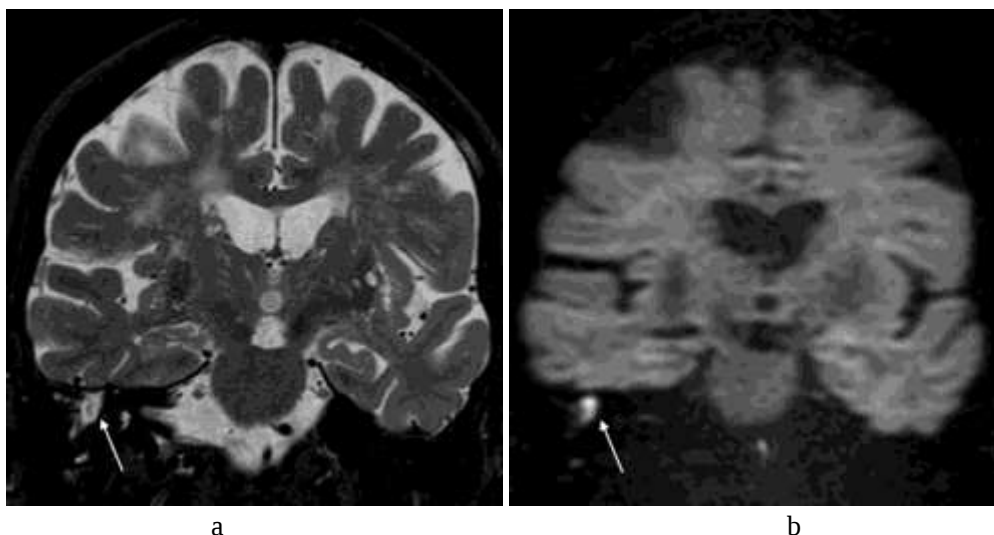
Chronic otomastoiditis with cholesteatoma (same patient shown in figure 12); coronal T2-weighted fast spin echo sequence with fast saturation (a) showing unspecific high signal intensity inflammatory tissue in the middle ear cavity (white arrow). A coronal non-echo planar DWI sequence (b) well demonstrate the cholesteatoma within the unspecific fluid collection as a bright comma shaped lesion (white arrow).
